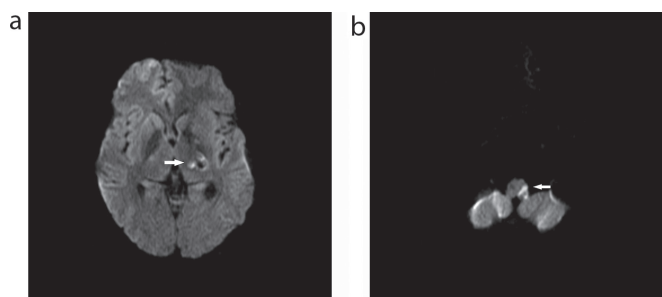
a,b. (a) Axial diffusion-weighted MRI scan on the second admission of the patient showing lesion with high signal intensity in the posterior limb of the left internal capsule (arrow), (b) A second lesion is depicted in the left lateral part of the medulla oblongata in the brainstem (arrow).
